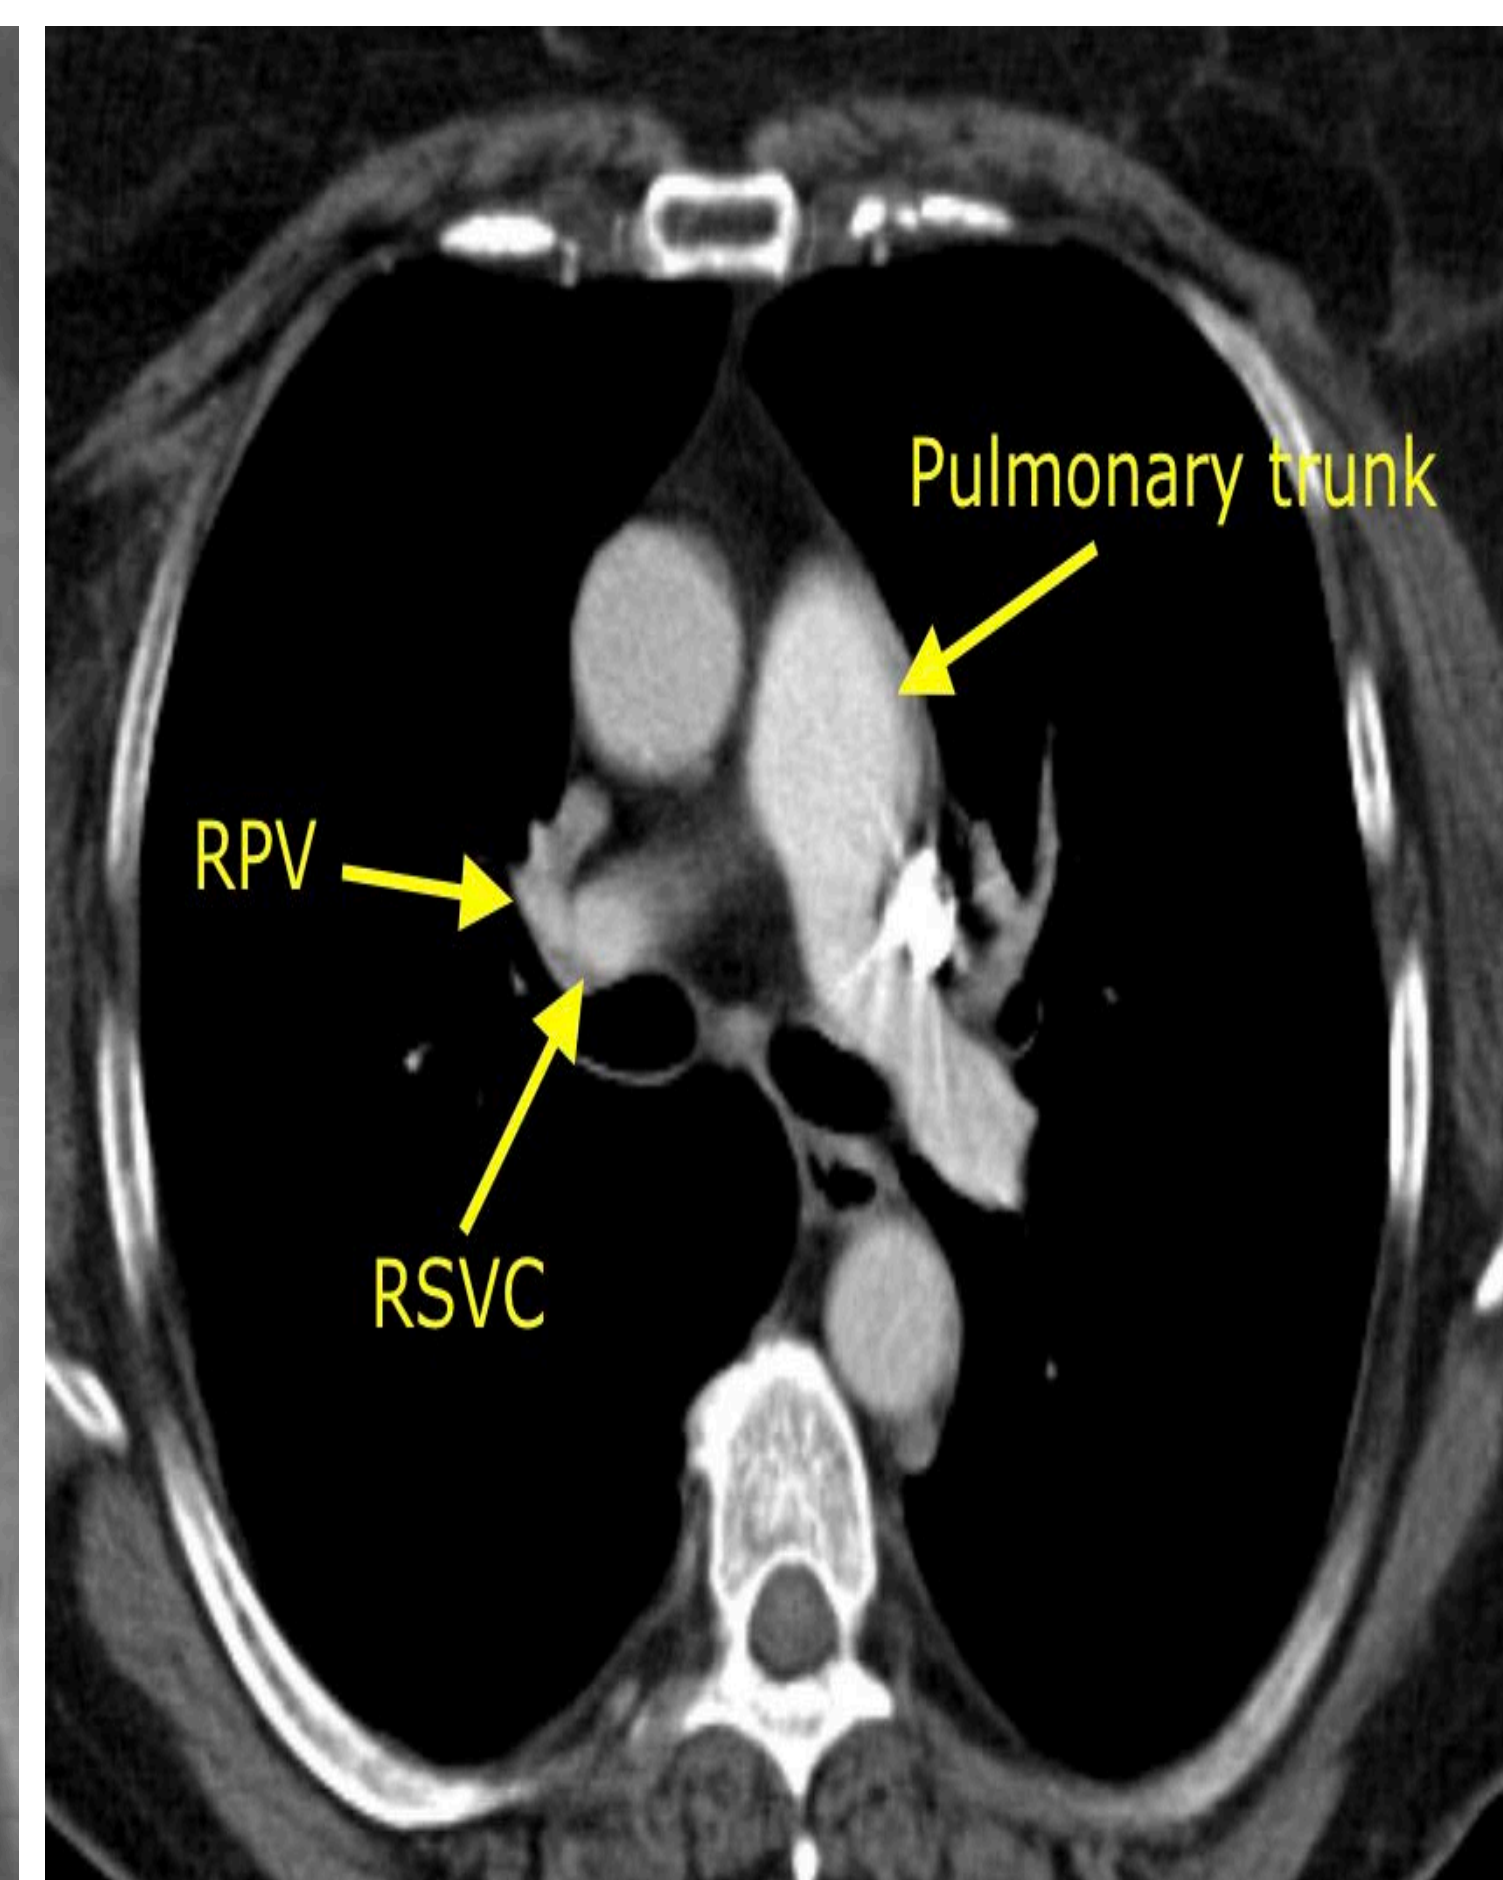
CT Chest showing RPV draining into RSVC
